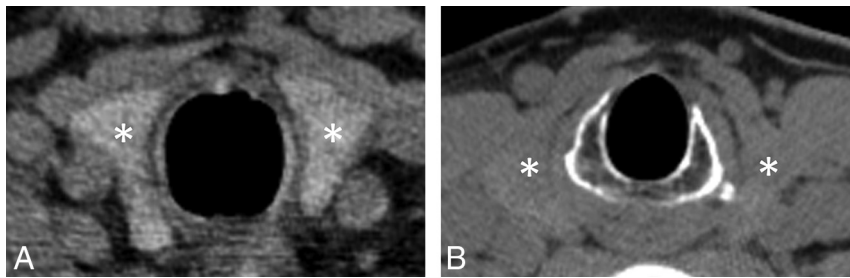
Axial, noncontrast, single-energy CT image (A) obtained in a patient with normal thyroid function demonstrates the normal hyperattenuating appearance of the thyroid gland (asterisks, A) relative to adjacent soft tissue. When present, this normal hyperattenuating appearance enables differentiation of parathyroid lesions adjacent to the thyroid gland from exophytic thyroid tissue. In contrast, the axial noncontrast single-energy CT image (B) obtained in a patient with long-standing Hashimoto disease demonstrates an iodine-deficient thyroid gland (asterisks, B), appearing nearly isodense to muscle, which renders differentiation of parathyroid lesions from exophytic thyroid tissue more difficult.
